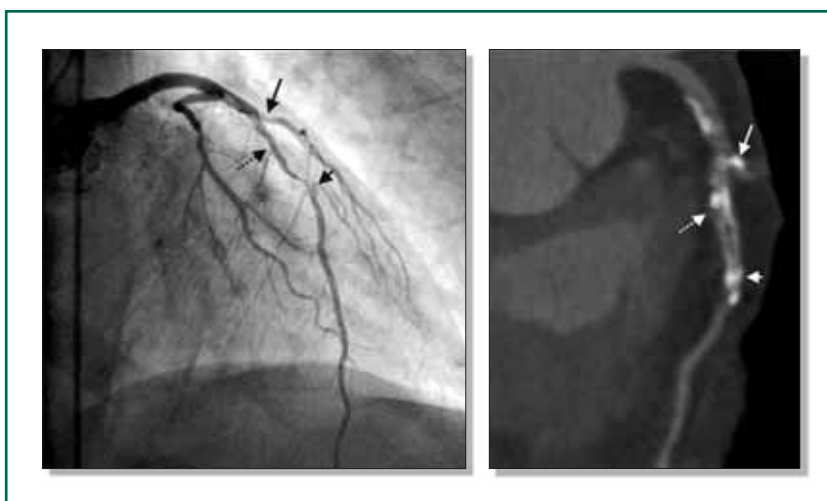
Calcified left anterior descending (LAD) coronary artery stenosis. Same patient as in Figure 1. The dual-source computed tomography coronary angiography (CTCA) image (right panel) shows the first diagonal branch (white arrow) with a calcification at its take-off from the LAD, mimicking an ostial stenosis. The septal branch (dashed black arrow on the conventional angiogram (left panel) and white on the multislice computed tomography (MSCT) (right panel) seems to take off from a subtotal LAD stenosis in the CT image. However, the conventional angiogram does not show a stenosis at this level. The stenosis in the conventional angiogram is marked by the short black arrow. This stenosis is not well depicted due to the presence of calcification. Interestingly, the bulky calcification adjacent to the vessel is not shown on the CT images.
